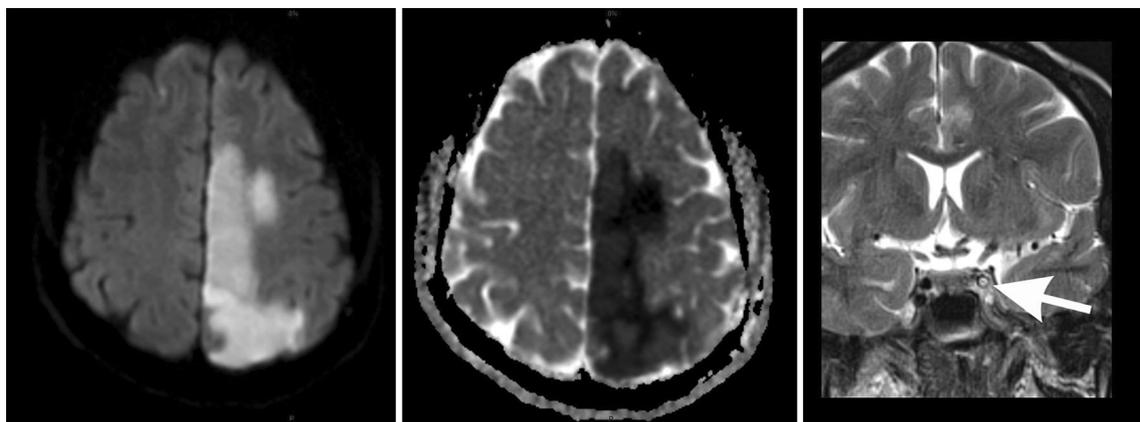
Acute left frontal–parietal ischemic lesion on diffusion-weighted image (*left*) and apparent diffusion coefficient (*center*) on magnetic resonance imaging of the brain. On the right side, is a
